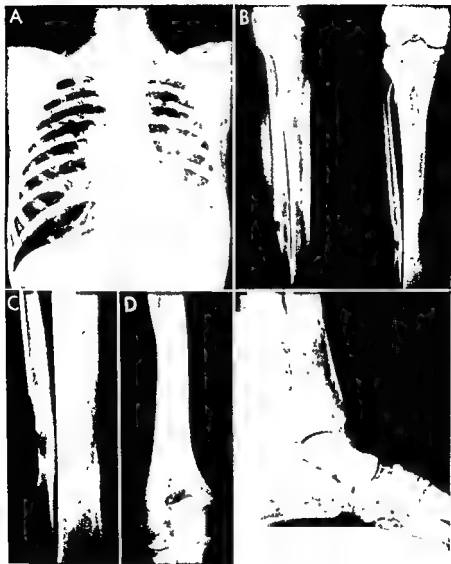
Radiographs of the chest (A) and the lower extremities (B-E) showing fractures of the ribs, femur, tibia, and ankle.
